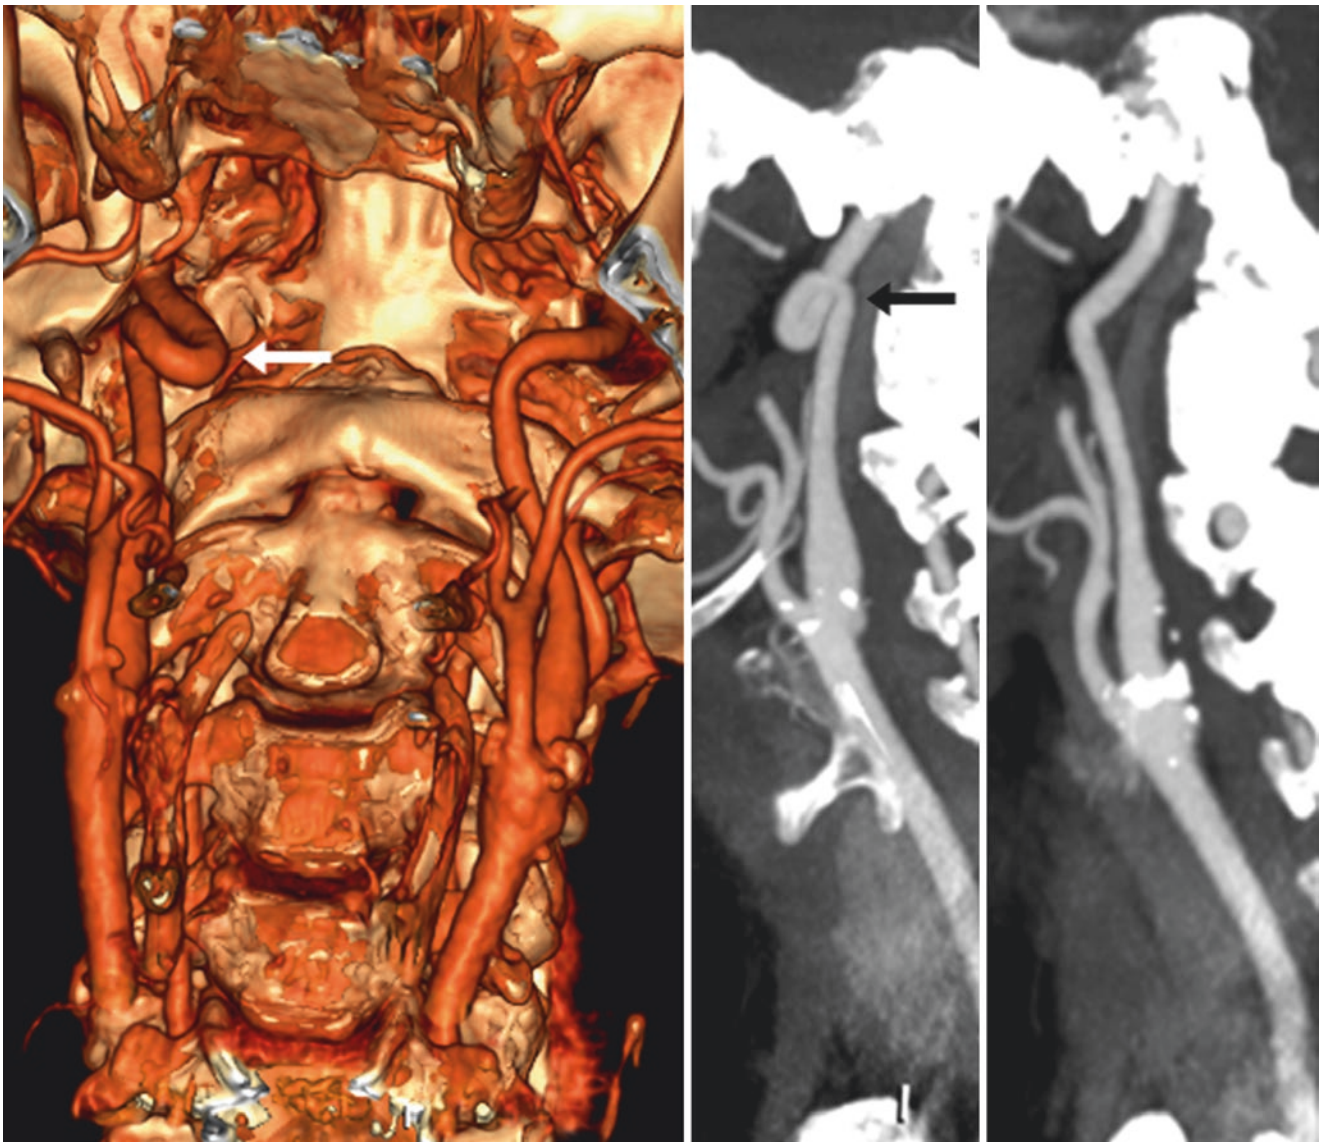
64-year-old with right ICA “kinking” (arrow) on a CTA with a 3D VR CTA AP view (*left*). Sagittal 15 mm-thick MPRs of the right (*middle*) and left (*right*) sides are compared side-by-side
